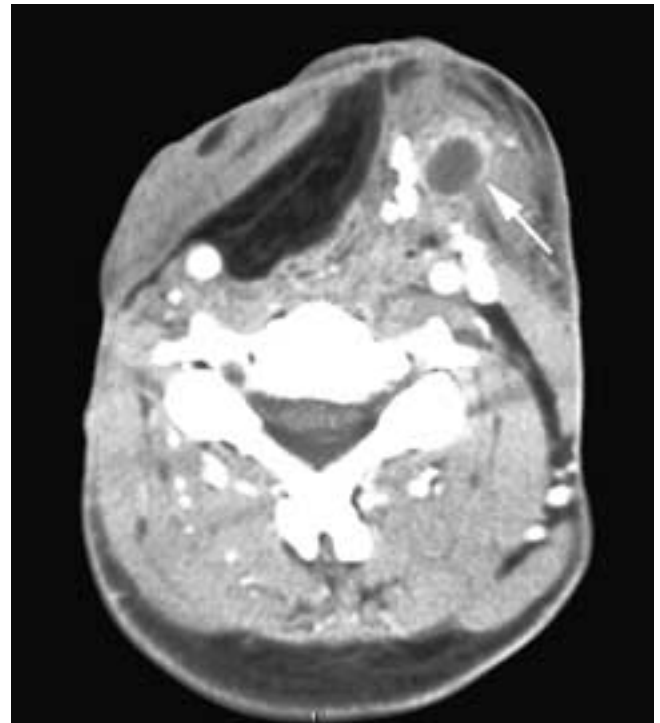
Axial contrast-enhanced CT scan on a patient who has had a total laryngectomy and a right neck dissection with flap reconstruction, and who received RT. Deep to the overlying soft tissues there is a necrotic area (*arrow*) of recurrent squamous cell carcinoma. This was not identified clinically, in part, because of the “woody” nature of the more superficial irradiated soft tissues.
